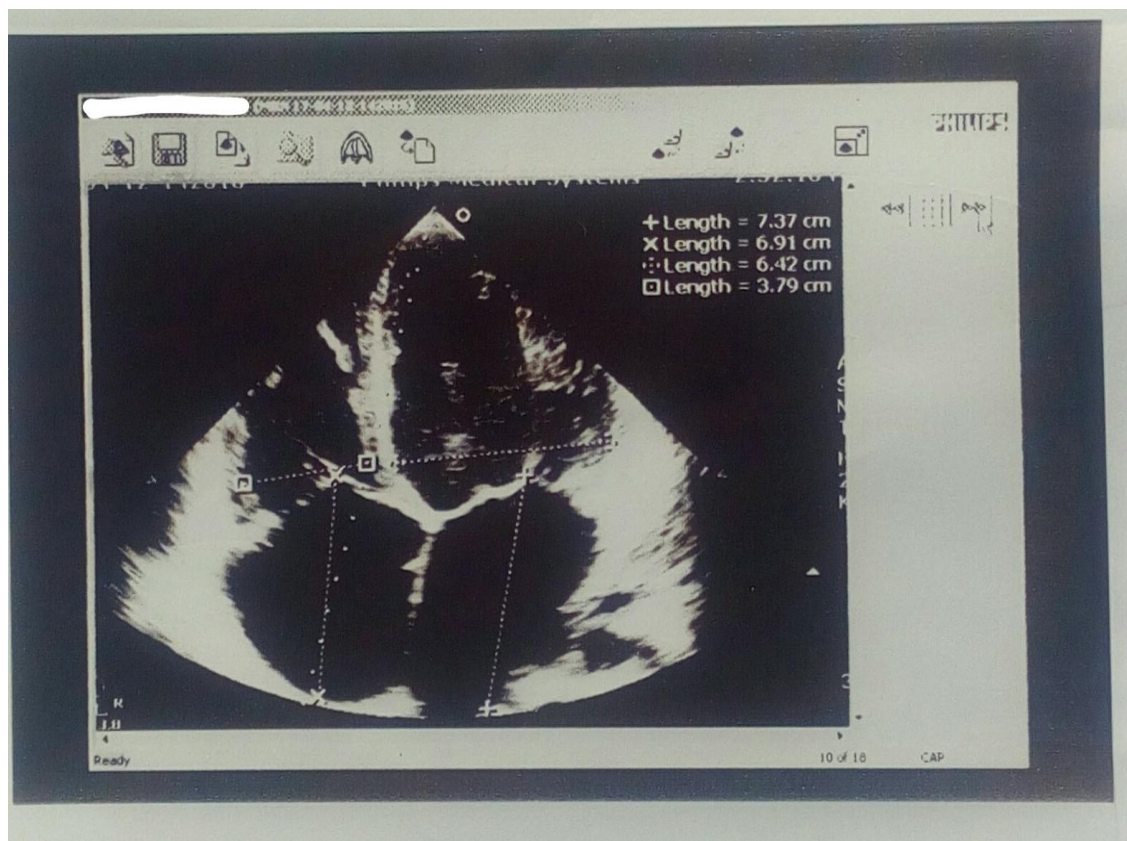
Apical 4 chamber view on echocardiography
